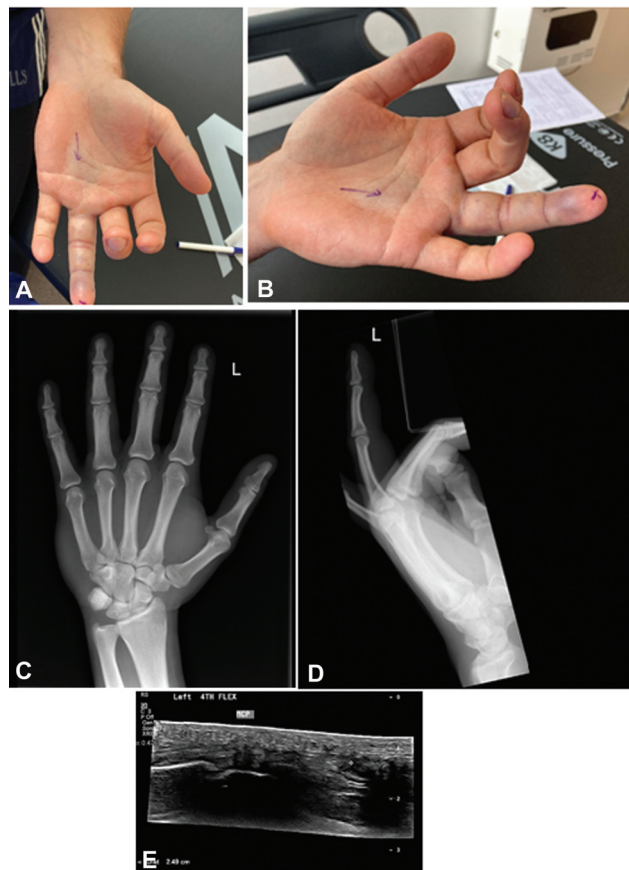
(A, B) Clinical presentation. (C, D) X-ray images at presentation with no bone avulsion injury. (E) US images showing a reported 2.49-cm gap in the FDP tendon. FDP, flexor digitorum profundus; US, ultrasound.
